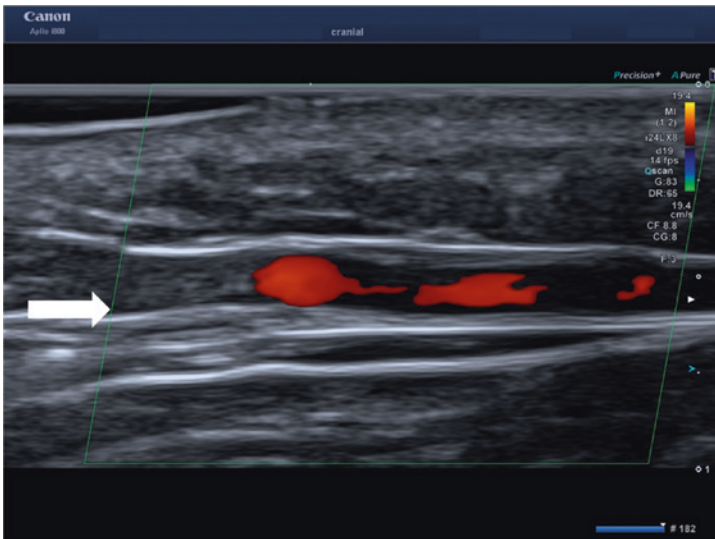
Pseudohalo. Anechoic halo due to low color Doppler gain, high PRF or wrong angle of insonation (white arrow). The color doesn't fill the vessel lumen completely
